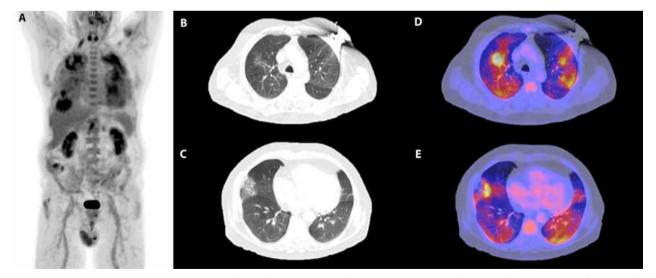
(A) Repeat FDG-PET/CT was performed following myocardial suppression protocol to exclude reactivation of CS. (B, C) Chest CT axial images showed multiple ground glass opacities and reticulations within both lungs. (D, E) These changes were associated with intense hypermetabolism on FDG-PET/CT images (SUVmax=8.1).
